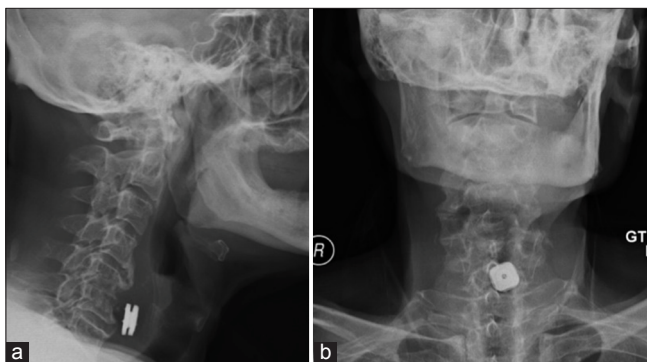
(a) Lateral and (b) anteroposterior X-ray showing the anterior dislocation of the prosthesis after the trauma.
